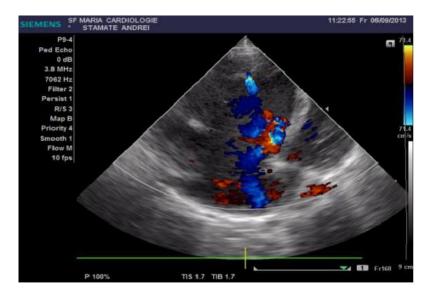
2D TTE - Doppler mode, apical 4 chambers view- Mitral regurgitation and dilation of the RV in a patient with Ebstein's anomaly
